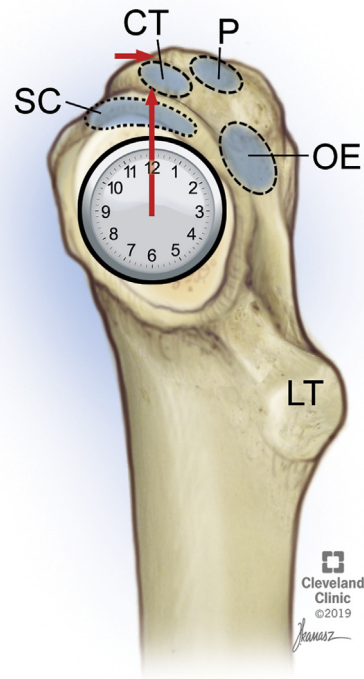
Clockwise release with reference to the right hip. SC, superior capsule; CT, conjoint tendon insertion; P, piriformis tendon insertion; OE, obturator externus tendon insertion; LT, lesser trochanter.
